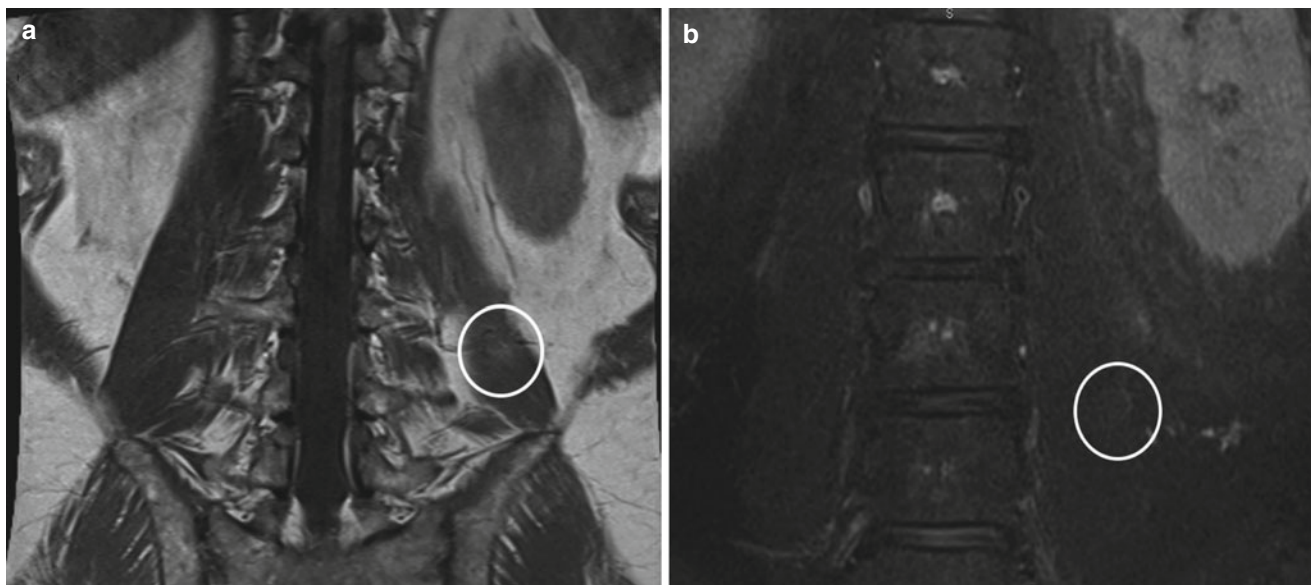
MRI showing psoas lesion, circled in white. (a) T1 sagittal image; (b) T2 sagittal image with contrast (note ring enhancement of the lesion) (Image courtesy of Andrea Trescot, MD)
